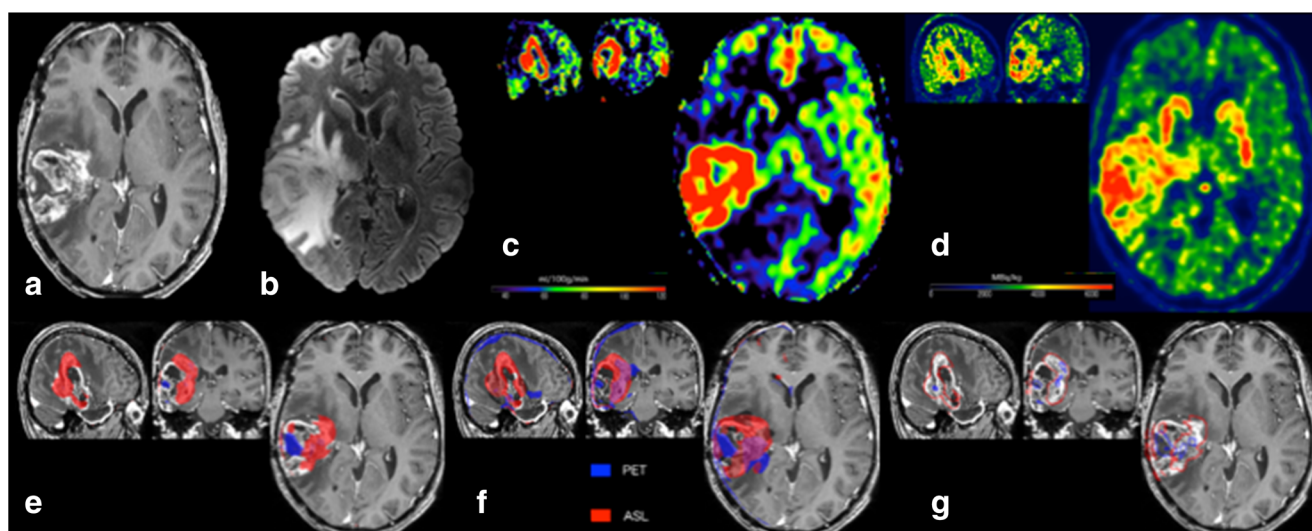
PET-MR of a 44-year-old female patient with a right-sided glioblastoma WHO IV without IDH mutation, treated by surgery and adjuvant radio-chemotherapy. The tumor progression was confirmed by the follow-up (true positive for ASL and PET). Upper row: a Enhancement at the initially treated parietal tumor site on a contrast-enhanced axial T1-w image. b Axial FLAIR-w image. c Hyper-perfusion with increased CBF
